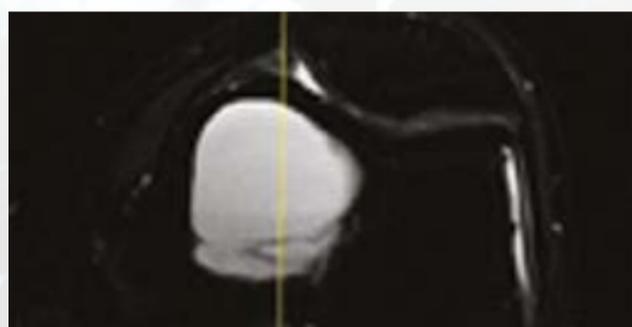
Transverse section of the left lower thigh (MRI).
